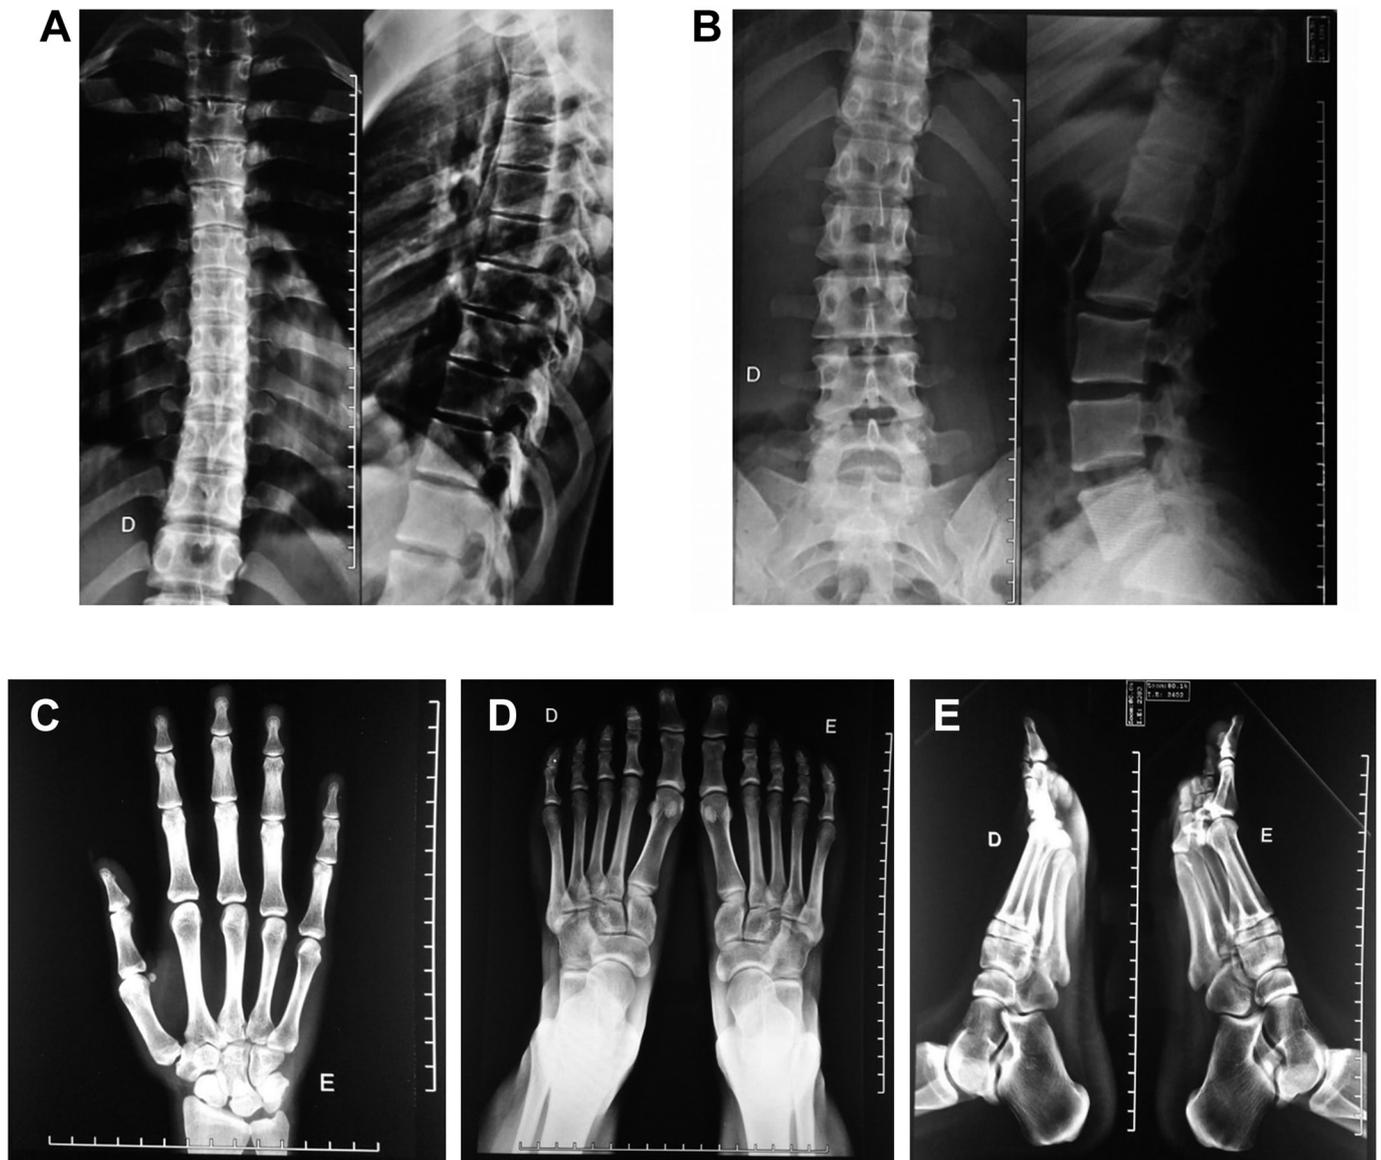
Minimal skeletal effects of HPP on the proband. Images were acquired before asfotase alfa treatment, when the proband (III.4) was 20 years old. Lateral and dorsal radiographs of the spine from (A) cervical/thoracic and (B) lumbar/sacral regions reveal discrete lumbar scoliosis (indicated by arrow). Vertebral bodies were preserved and no significant reductions of intervertebral disc spaces were observed. (C) A radiograph of the left hand shows no evidence of metaphyseal fraying or characteristic “tongues” of radiolucency. Radiographs showing frontal and lateral views (D and E, respectively) of the feet show no signs of fractures or pseudo-fractures, with an absence of gross bone irregularities and pathological calcifications, and articular spaces that appear normal and free of ectopic calcification. The skeletal age of the proband (III.4) was estimated to be 17 years according to the Greulich–Pyle (GP) method.
